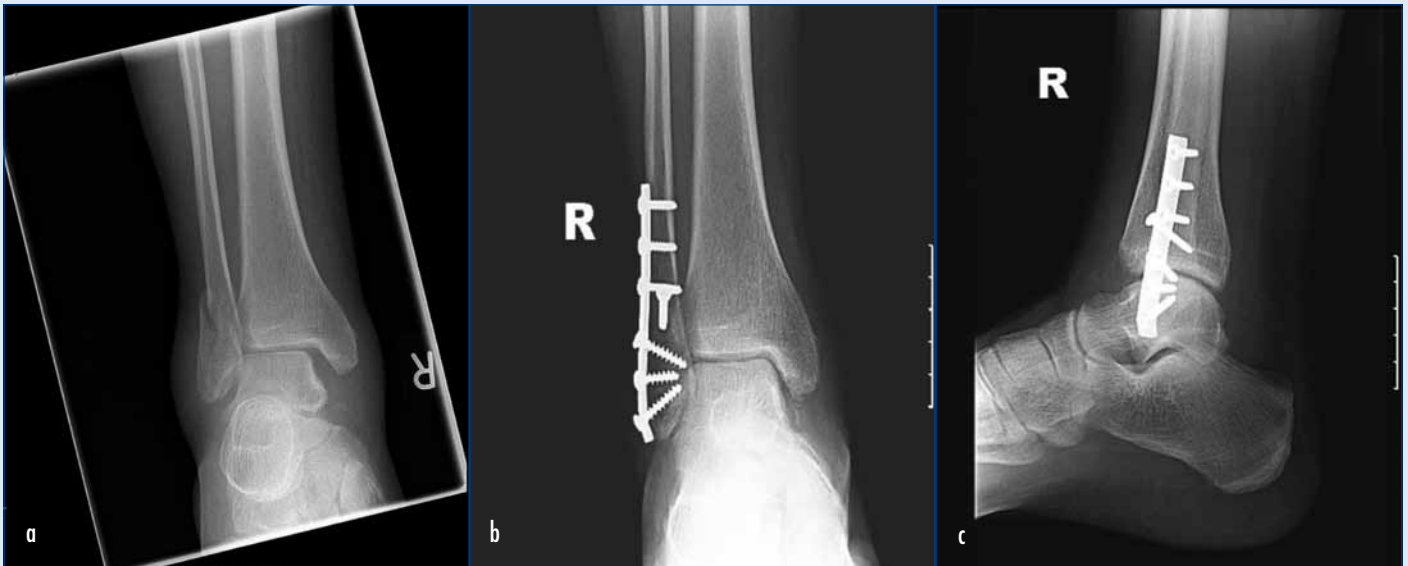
a. Anteroposterior X-ray of a Weber B fracture. b. Open reduction internal fixation of the fracture in anteroposterior and (c) lateral views.
